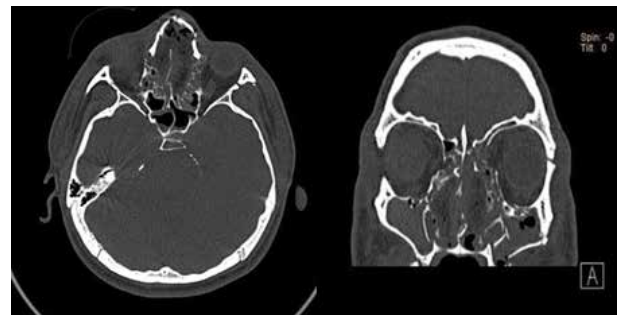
Preoperative CT scan. Case 2.
